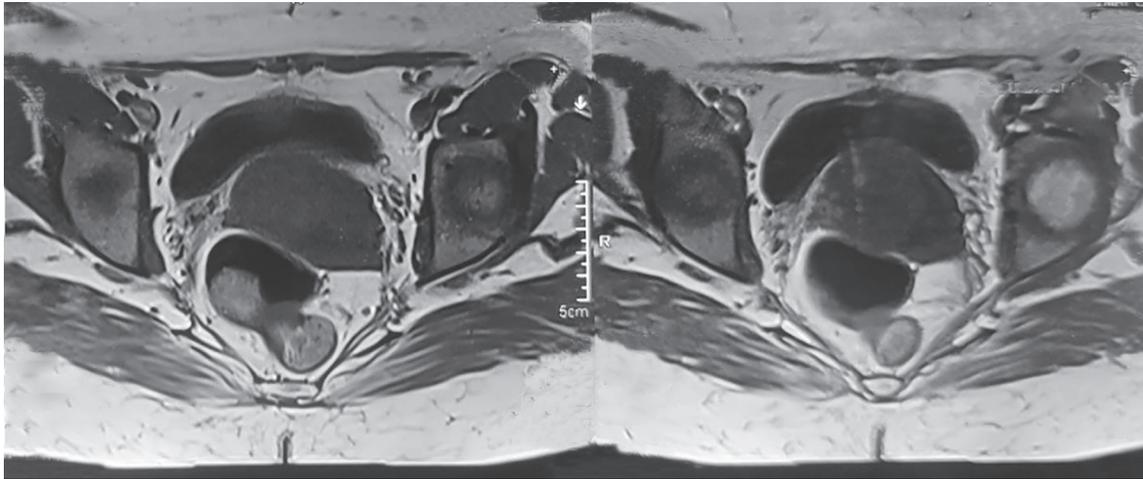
Post-neoadjuvant chemotherapy MRI showing residual disease
